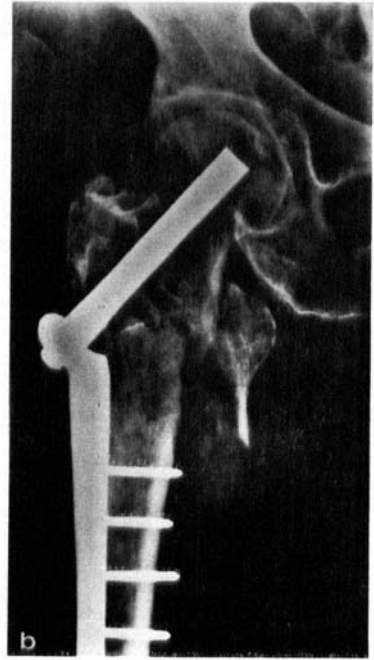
Subtrochanteric fracture of the femur from metastasis of mammary carcinoma, preoperative X-ray (a). Osteosynthesis with a McLaughlin nail plate (b). Bony consolidation appeared after postoperative radiotherapy, although owing to collapse of the destruction area the nail was driven in cranial direction in the collum. The continuation of destruction, more distally, points to the prophylactic significance of a long side plate (c, 16 months after operation). Powerful calcinosis of femoral artery appeared after the fracture.
